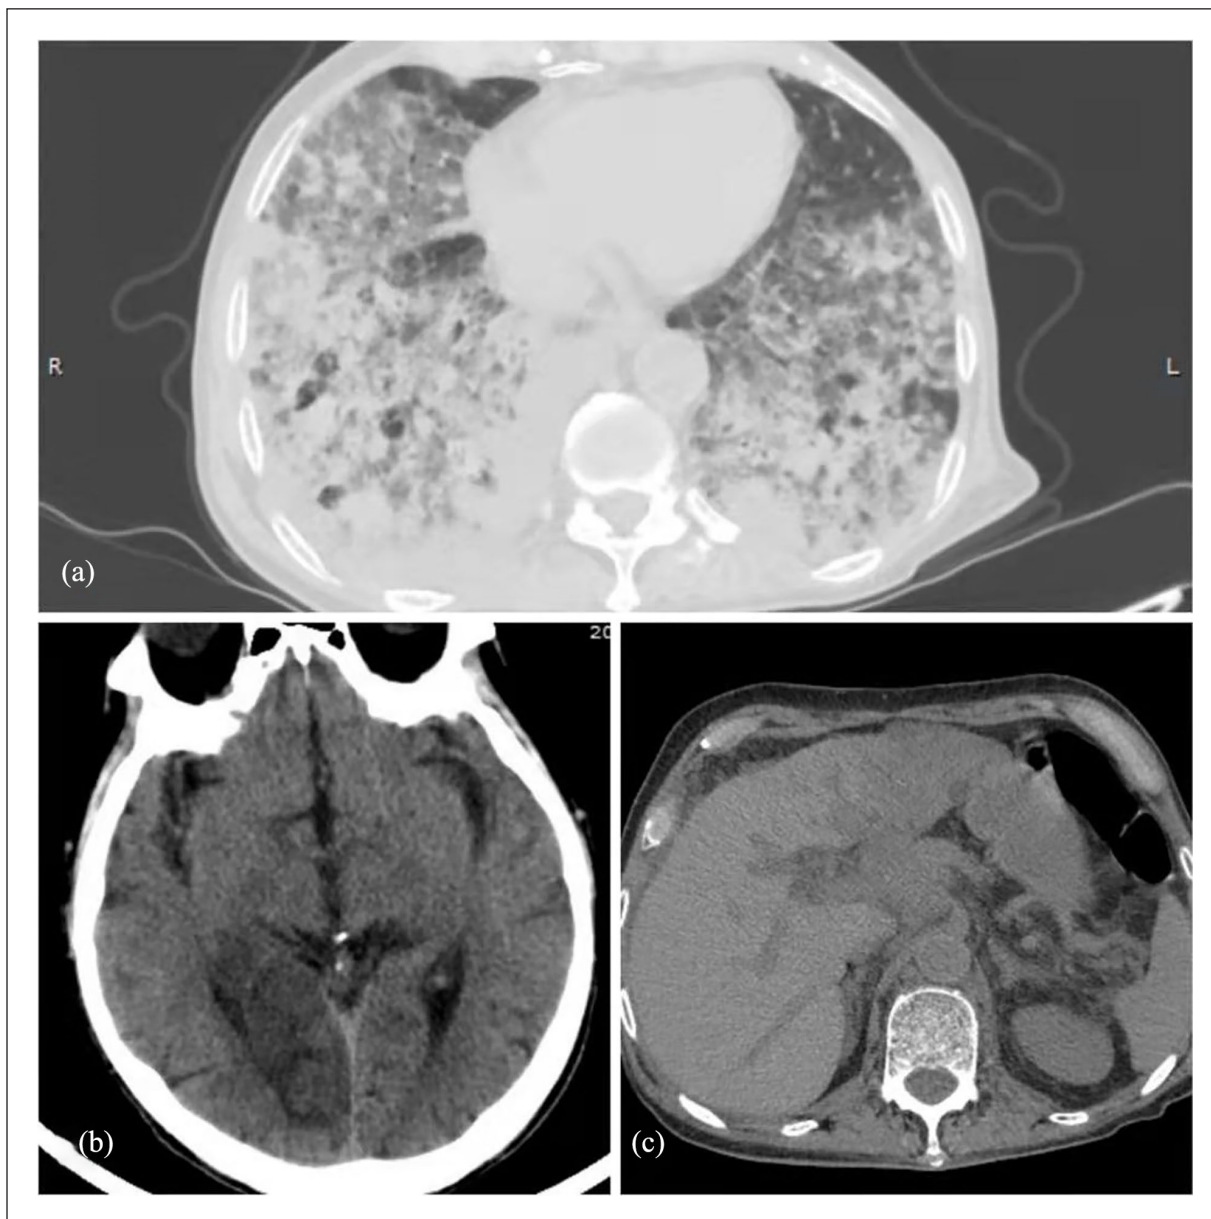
Computed tomography review results. (a) Progression of lung lesions; (b) progression of brain metastases; (c) progression of liver lesions.
